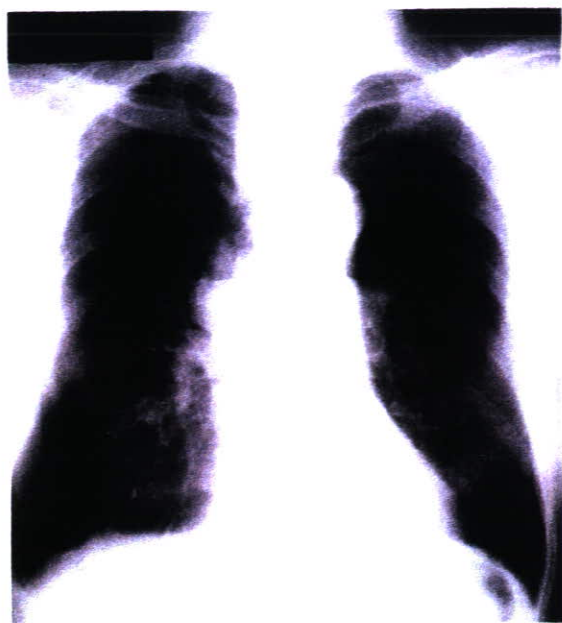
Chest X-ray film showing a mass shadow in the right hilum
